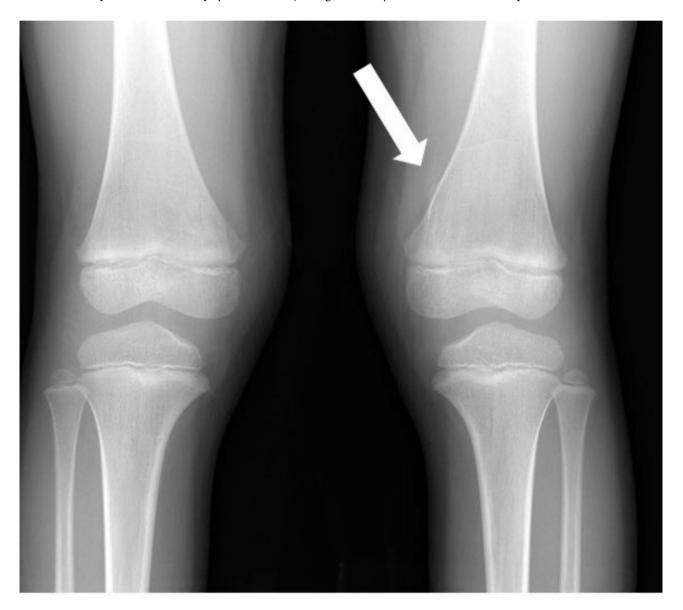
Knee radiograph showing a slight elevation of cortical bone inside the distal femur indicated by an arrow
